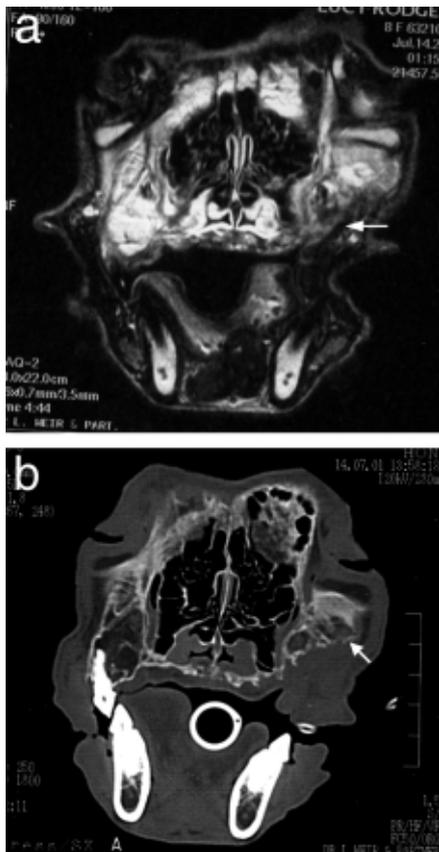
a. A transverse T<sub>2</sub>-weighted MR image of patient 2. The entire hyperintense region is abnormal. Previously performed surgery of the left maxillary region (arrow) made delineation of the tumour from granulation tissue impossible. Diagnosis: osteosarcoma. b: Patient 2. Computed tomographic image of the same tumour showed that the entire cranium is affected. Extensive bone destruction is evident. The surgical site can clearly be seen (arrow).
